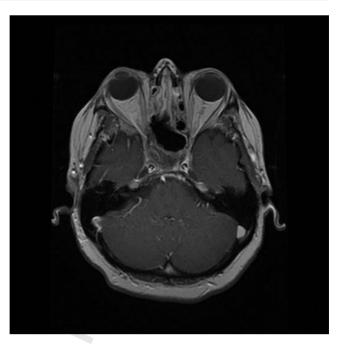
MRI of the head after the surgery with postoperative changes and without residual tumour.
